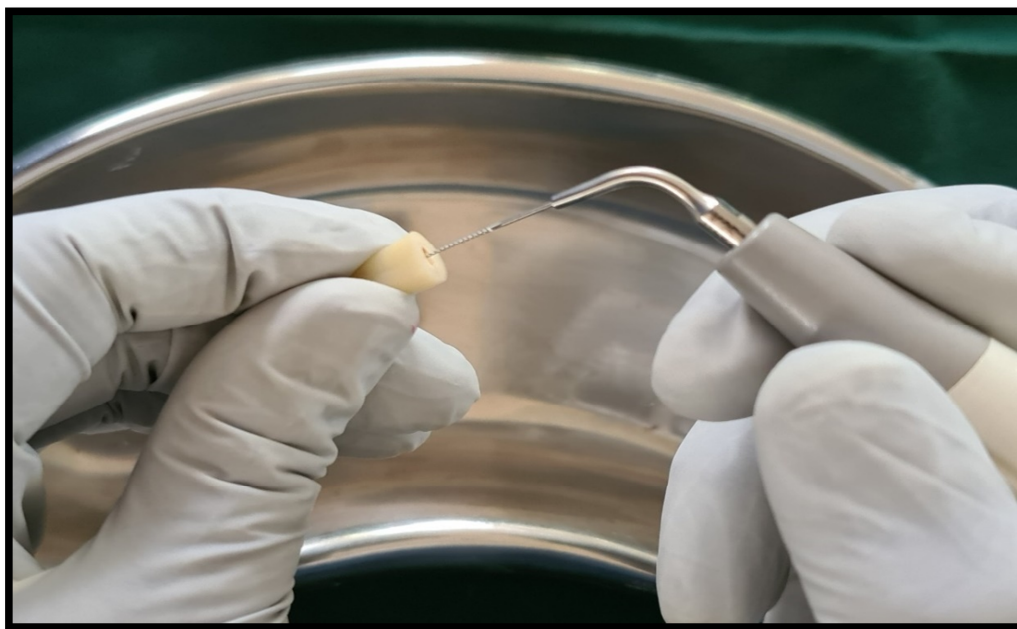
Passive Ultrasonic Irrigation
